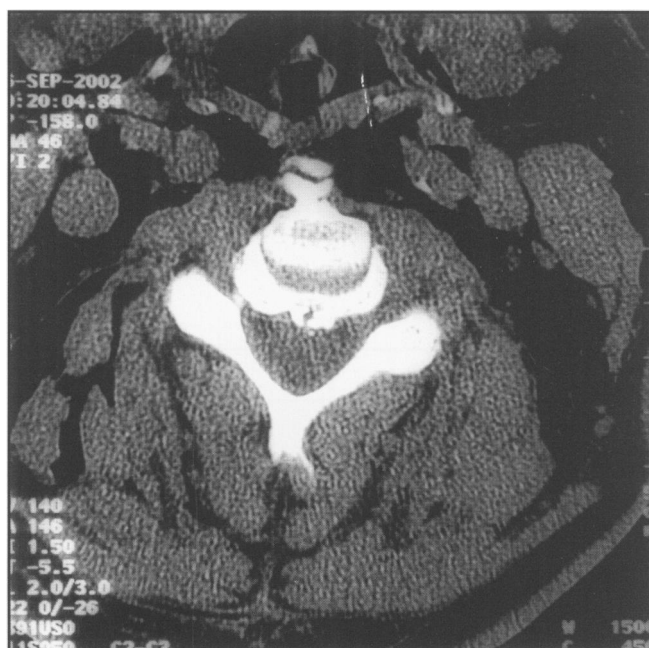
CT neck examination confirming gross surgical emphysema of the neck.
